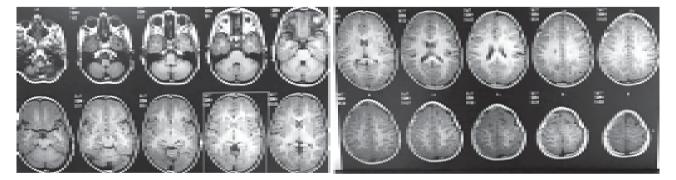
MRI Brain contrast (T2/FLAIR) - Symmetrical confluent hyperintensities involving bilateral periventricular regions in frontal and occipital regions and T2 hypodensity in bilateral thalami
